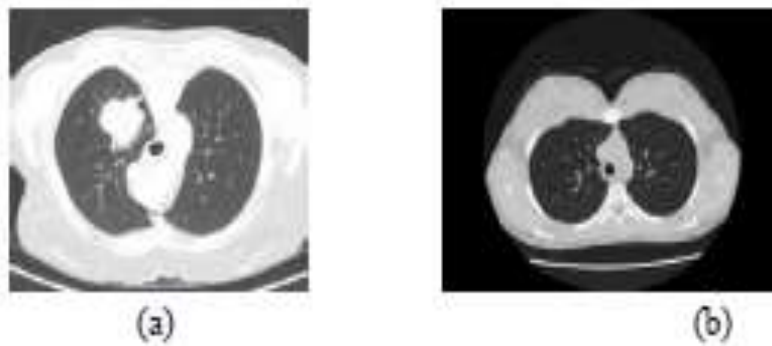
CT scan image (a) Lung without tumour (b) Lung with tumour
